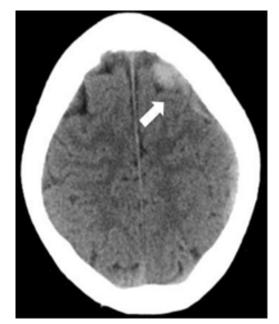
Transverse section of a computed tomography image of the head showing an acute subdural hematoma along the left frontal cerebral hemispheric convexity (arrow).
